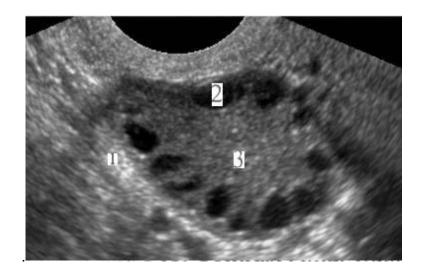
Ultrasound characteristic features of PCOS: (1) Thickened capsule, (2) cysts (12 in total) and (3) Increase in stromal echogenicity www.gynaeonline.com/images/pcos.jpg
